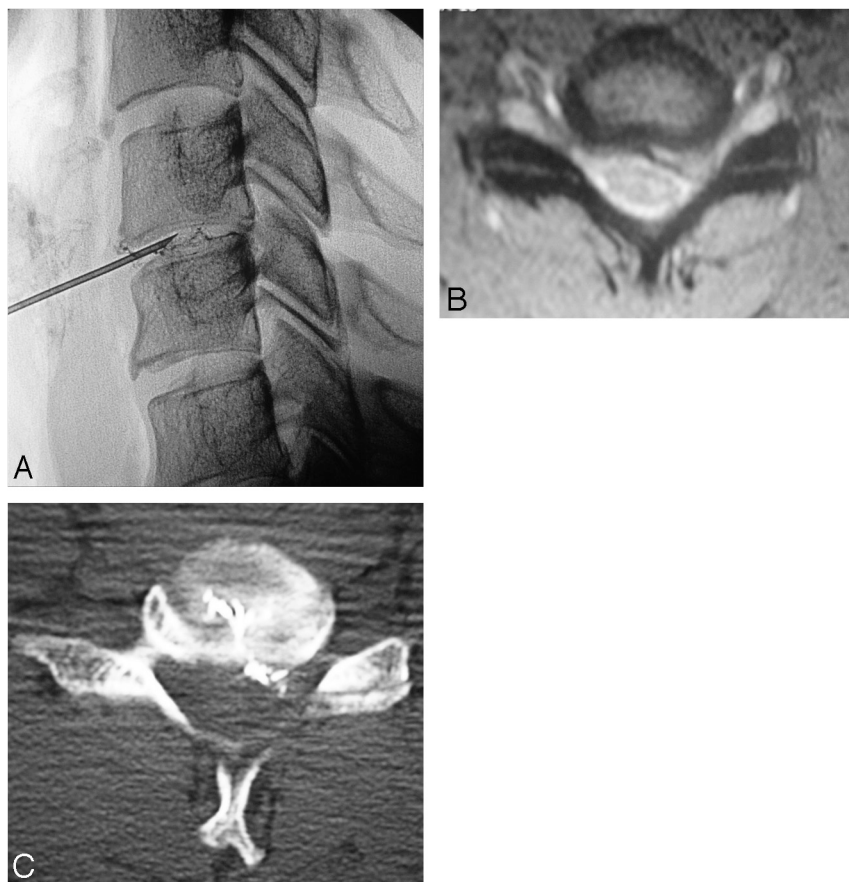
Cervical disk hernia. *A*, Lateral fluoroscopy during injection of radiopaque gelified ethanol. *B*, MR image obtained before treatment. *C*, CT scan obtained after treatment showing the radiopaque gel following the fissure of the disk and penetrating the extruded fragment.
